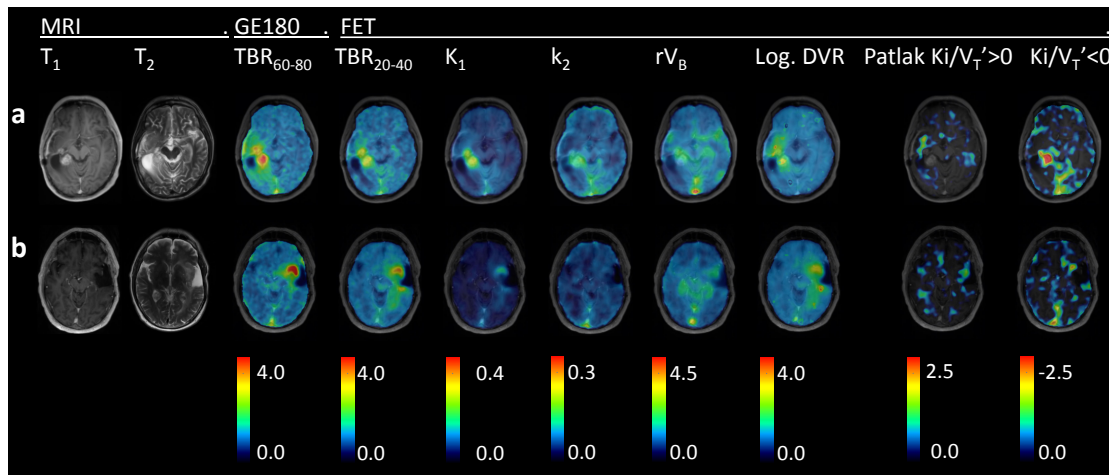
Two exemplary *IDH*-mut HGG gliomas (patient a and b) scanned with contrast-enhanced MRI,  $^{18}\text{F}$ -GE-180 PET, and  $^{18}\text{F}$ -FET PET. From left to right: CE  $T_1$ -weighted MRI,  $T_2$ -weighted MRI, static  $\text{TBR}_{60-90}$  from  $^{18}\text{F}$ -GE-180 PET, and parametric images from  $^{18}\text{F}$ -FET PET: static  $\text{TBR}_{20-40}$ ,  $K_1$  and  $k_2$  from  $1\text{TC-}V_B$ , DVR from Logan reference tissue model, and positive and negative  $K_i/V_T'$  from Patlak reference tissue model.
